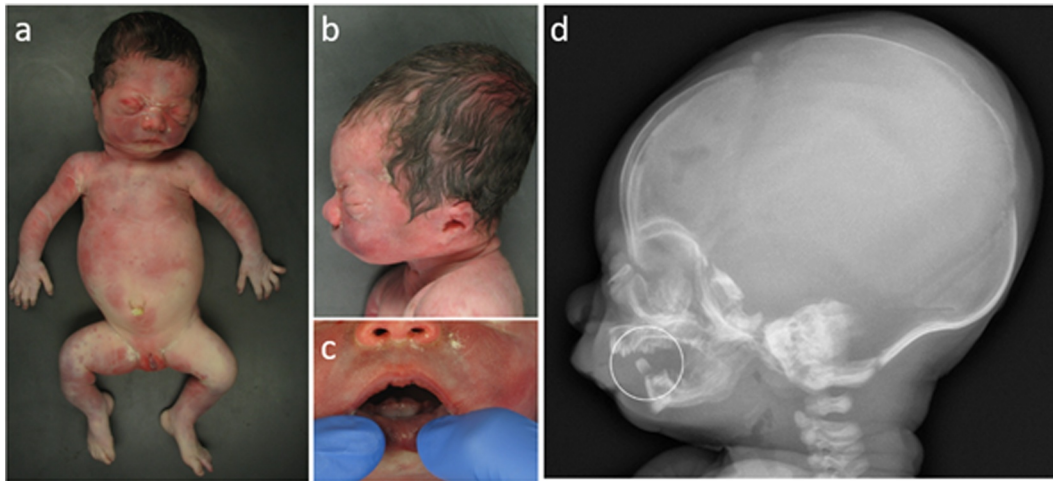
Fetopathologic and radiological examination of the proband of Family 1 (31 weeks of gestation). (A) Fetus with long bone bowing; (B) profile appearance; (C) thickened and irregular inferior gingiva; (D) profile X-ray view of the head of the fetus showing an intraoral radiodense lesion (circle). [Colour figure can be viewed at wileyonlinelibrary.com]
